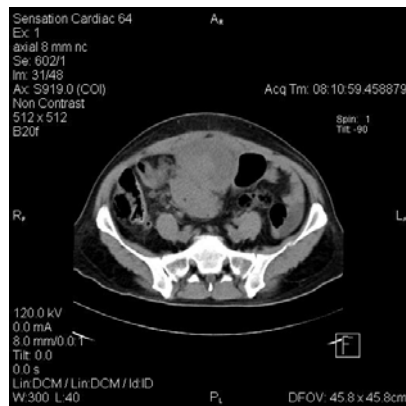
CT scan: abdominal mass infiltrating into the anterior abdominal wall
